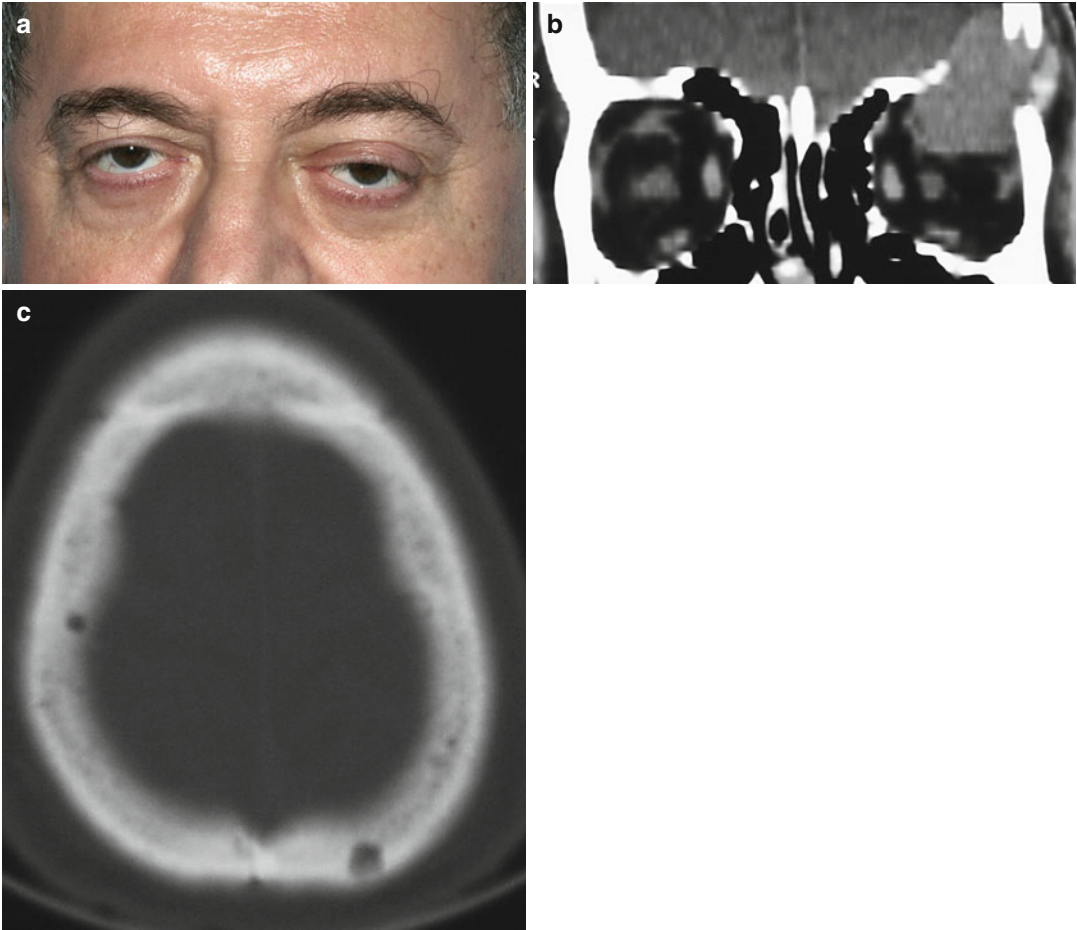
(a–c) Multiple myeloma. (a) Facial photography; (b) CT image of the tumor that causes bone destruction and spreads intracranially; (c) multiple lesions in the bones of the skull
